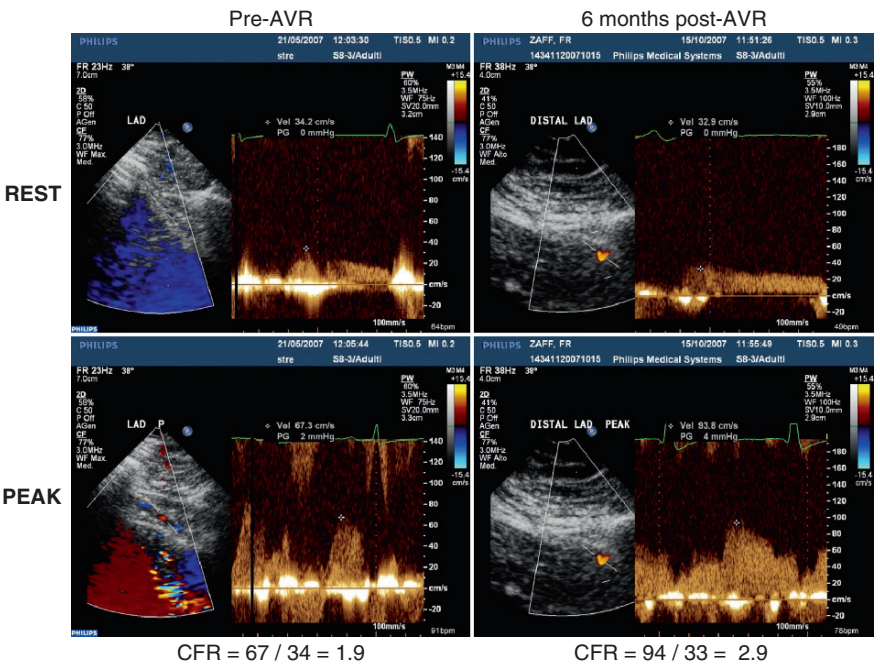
Coronary flow reserve (CFR) assessed at rest and during adenosine administration by transthoracic stress echocardiography in a patient with severe aortic stenosis and angiographically normal coronary arteries before (left panel) and 6 months after (right panel) aortic valve replacement (AVR). In the postoperative assessment, left ventricular hypertrophy is not yet regressed but CFR has substantially improved. (Courtesy of Dr. Fausto Rigo, Venice, Italy)
